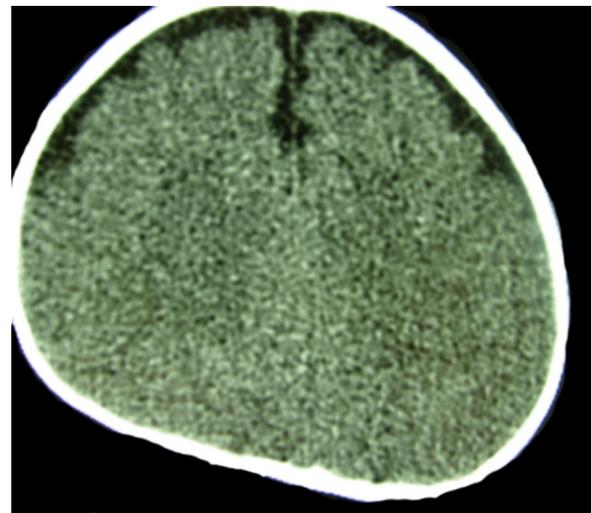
Axial CT slice showing position plagiocephaly. It is no longer recommended to use CT.
